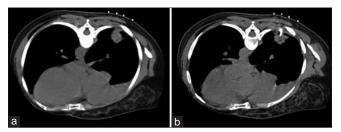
(a) Unenhanced chest CT showing right pulmonary Nodule with metallic Cannula Markers placed over the nodule and (b) 21G Needle used as a guide seen within the Nodule
